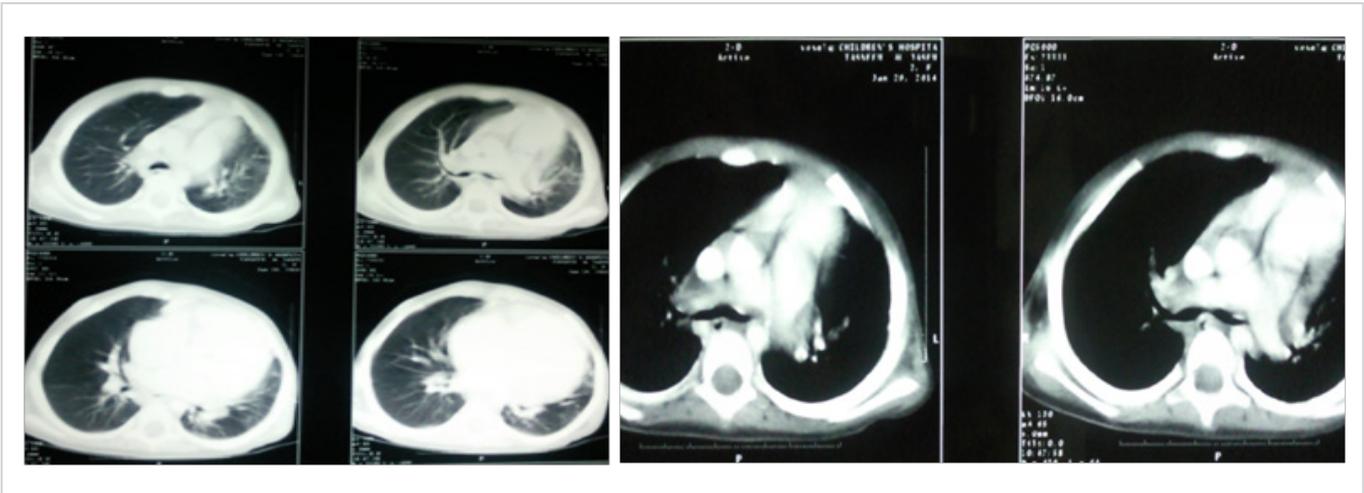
CT scan : cardiomegaly with dilated pulmonary artery
